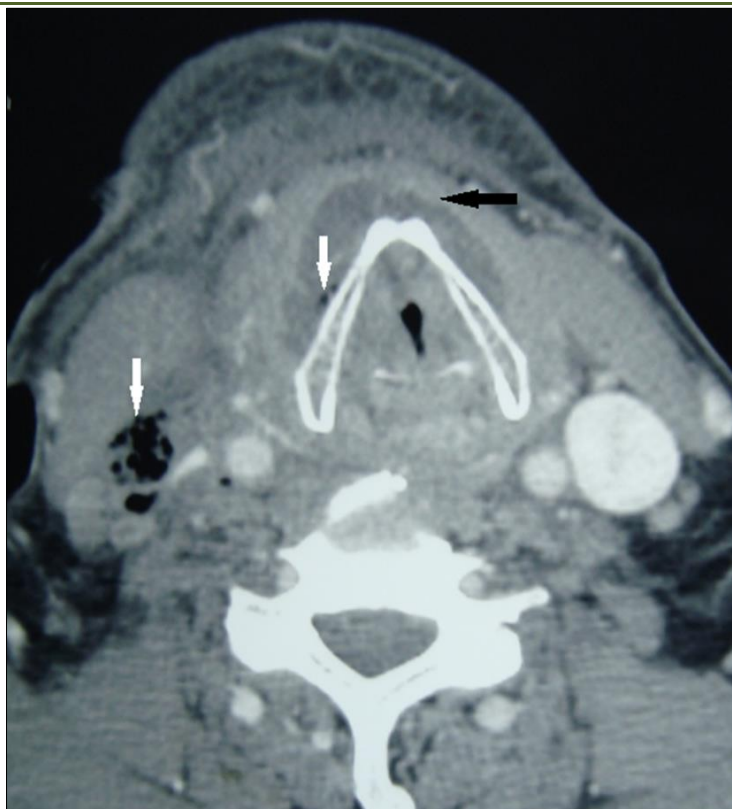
Enhanced computed tomography. Axial view at the level of the hyoid bone showing the compression of the internal jugular vein by gas formation and muscle swelling (arrow)
